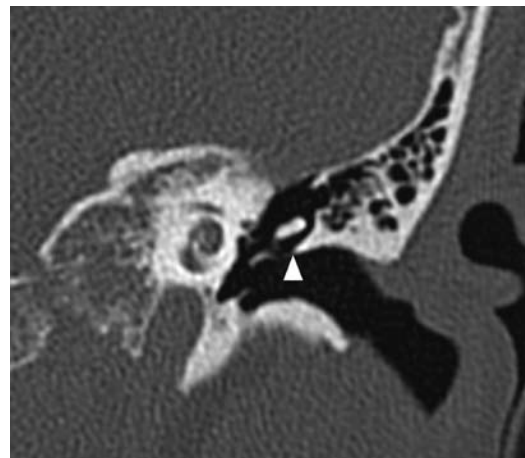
This is a coronal CT image of a temporal bone with no known middle ear pathology. It passes through the temporal bone at the level of the *cochlea*, and uses a bone window algorithm with a window width of 4,000 H. The scutum can be identified as the sharp-edged superomedial border of the external auditory canal (white arrowhead).
